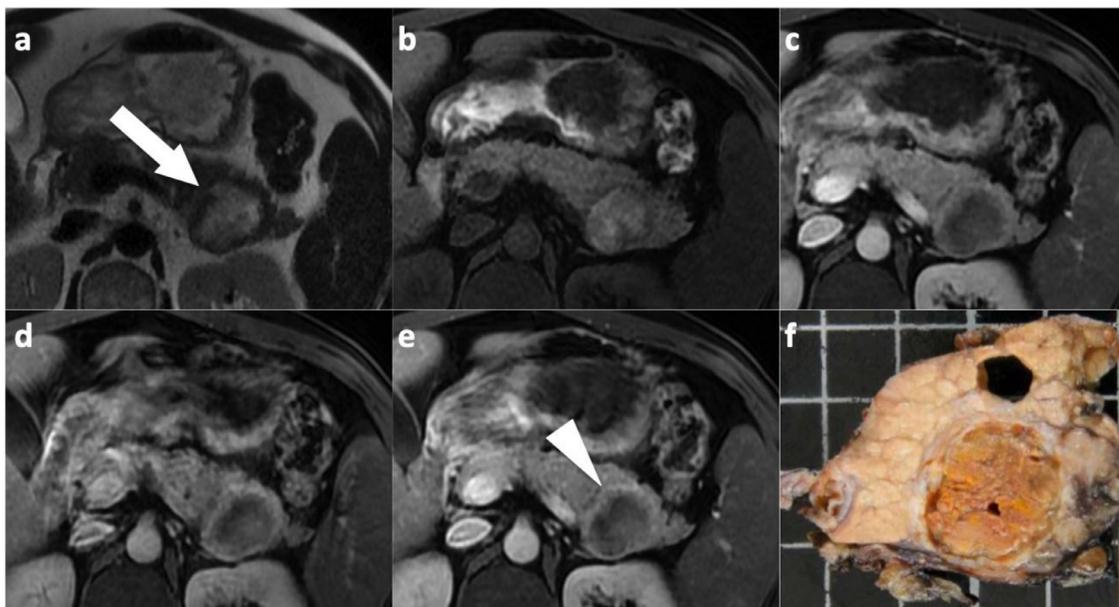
Solid pseudopapillary neoplasm in a 36-year-old female patient. Axial T2-weighted MR image (a) shows a large lesion (arrow) in the pancreatic tail with a heterogeneous central high T2 signal area including cystic portions. The lesion is hyperintense on precontrast (b) fat-suppressed T1-weighted GRE MR image, suggesting hemorrhagic content. Note the peripheral thick well-defined fibrous enhancing capsule (arrowhead), presenting with progressive enhancement on enhanced fat-suppressed T1 GRE MR images (c-e) obtained during portal (c), 3' (d) and 5' (e) delayed phase. Diagnosis of a solid papillary neoplasm was confirmed after surgery (f).
